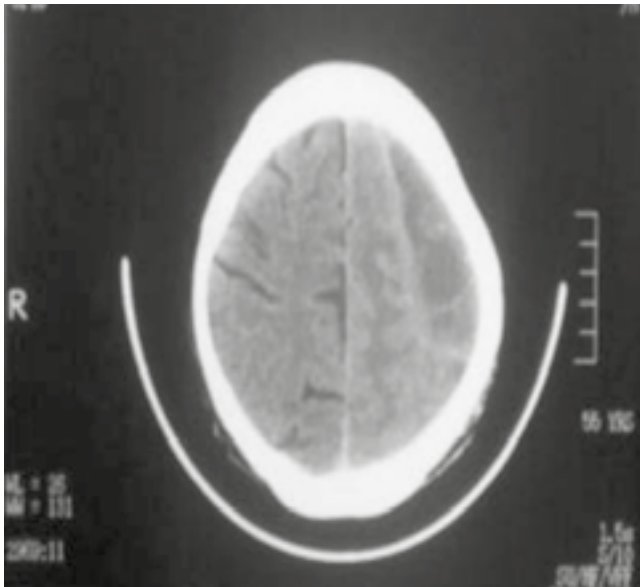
Pre op CT Brain of OCSDH
